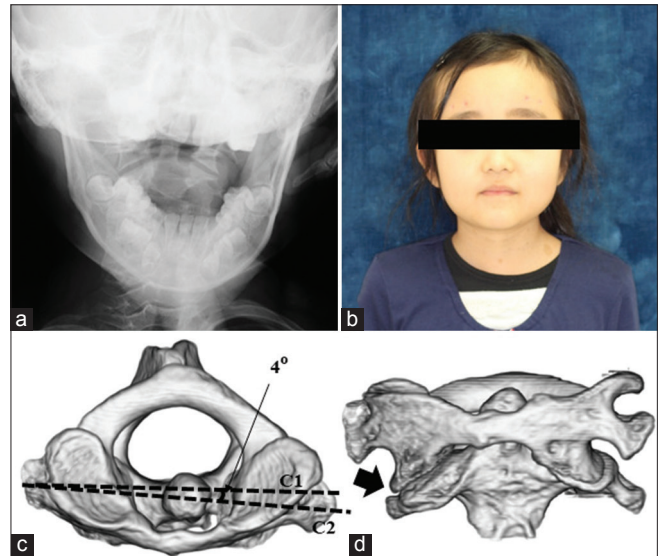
Photograph (a) and radiography (b) at 1 month after removing halo fixation. Three-dimensional computed tomography images in the axial (c) and anterior (d) views at 4 months after removing the halo fixation show normal alignment of the atlantoaxial joint and C2 facet deformity (arrow).
